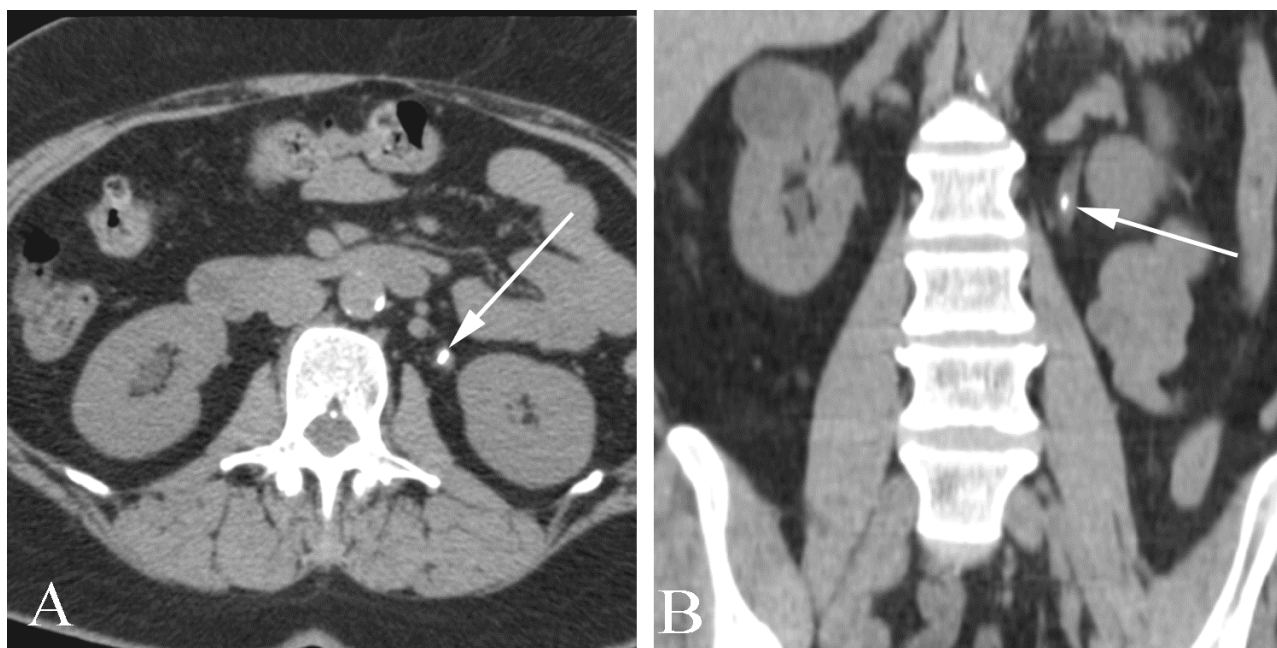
Renal stone in a 51 year old woman with asymptomatic hematuria. A. Noncontrast axial CT study shows a stone (arrow) at the left ureteropelvic junction. B. Noncontrast reformatted coronal CT (right) also demonstrates the stone (arrow). Incidentally noted is a cyst of the contralateral kidney.
